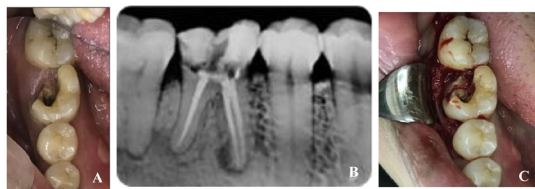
A. Clinical features of teeth 46, B. Dental radiography 46 seen vertical radiolucent lines on dental bifurcation and vertical bone loss was evident on mesial root, C. Flap opening
